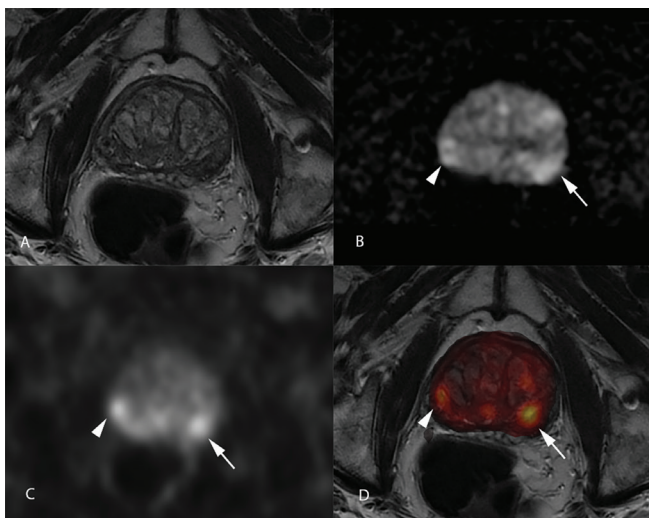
A 76-year-old male patient underwent PET-MR, although the cancer in the left peripheral zone is prominent on DWI (B) (arrow), the lesion in the right peripheral zone is more obscure on DWI (arrowhead). PET (C) and PET-MRI fusion images (D) shows both lesions more clearly. A shows T2W images. The biopsy result of the patient was gleason 4+3 in the left peripheral zone lesion and 3+4 in the right peripheral zone lesion
